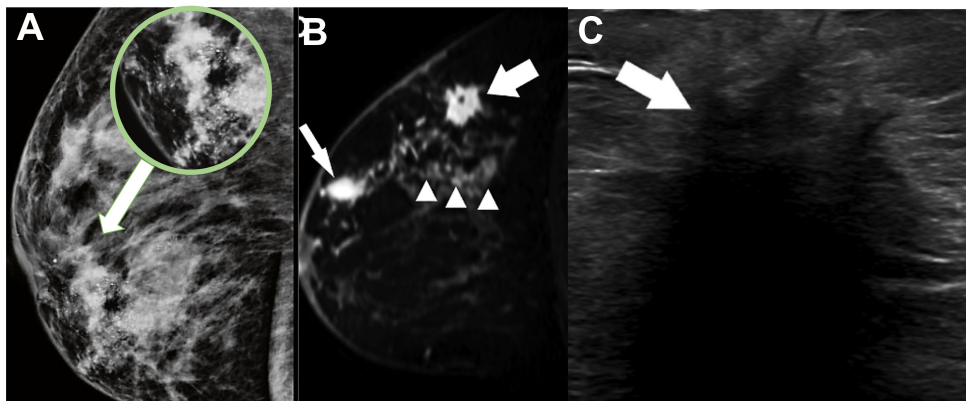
Imaging features of HER2 subtype. A) The mammography shows a mass with fine linear calcifications, B) MRI shows a non-mass multi-focal enhancement, and C) on US, the mass is hypoechoic with irregular margins.
